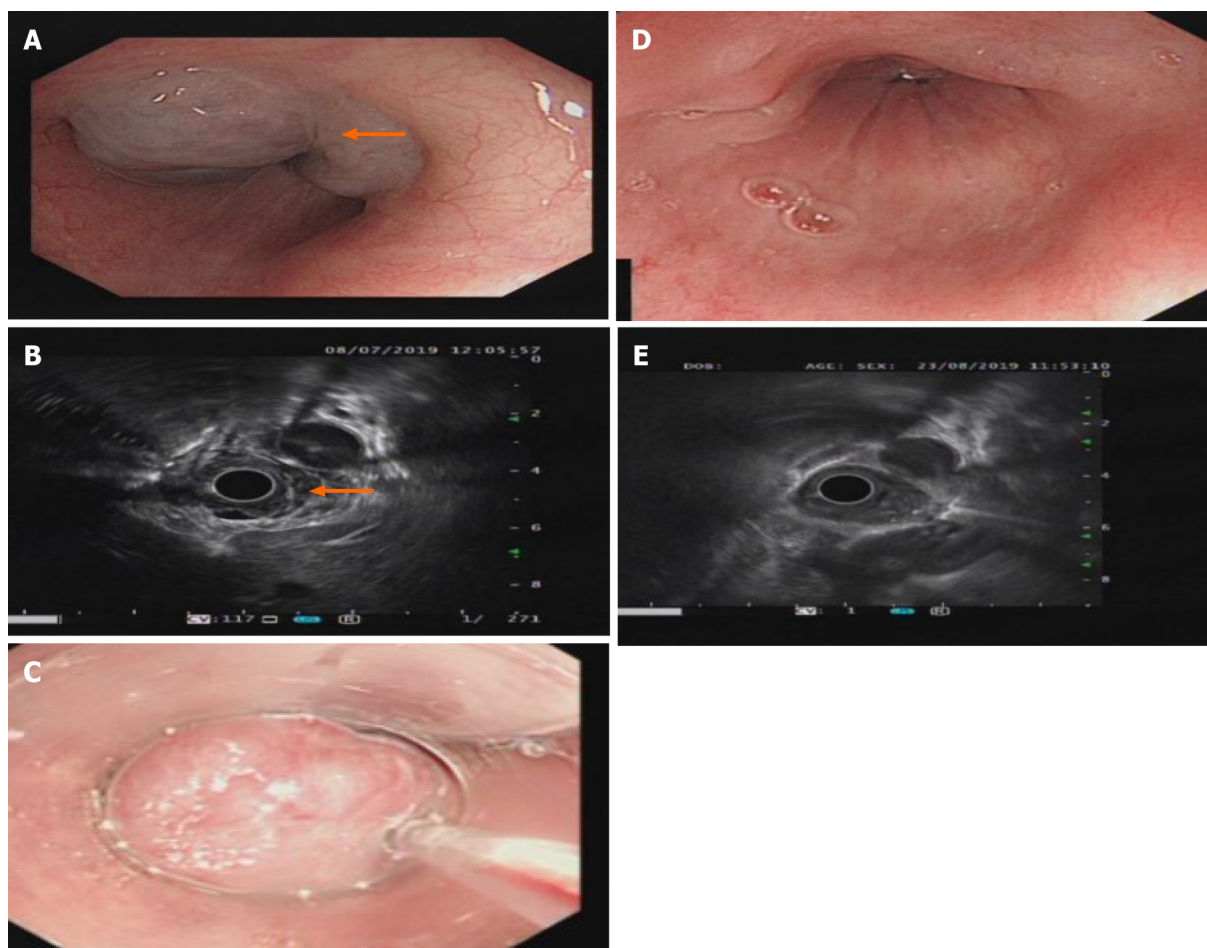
Gastroscopy and ultrasound images of the lower esophagus. A: Gastroscopy showing a bulge of about 4.0 cm × 4.5 cm × 2 cm in the lower esophagus. The mucosa was smooth and blue (as shown by the arrow in the picture); B: Endoscopic ultrasound showing lesions with multiple grids without echo structures and clear boundaries (as shown by the arrow in the picture); C: Twenty milliliters of polidocanol was injected into the hemangioma under a transparent cap with a 25G needle endoscope; D: The hemangioma at the esophageal lesion disappeared, and the mucosa was pink after treatment with polidocanol; E: Ultrasound showing that the non-echo structure disappeared after submucosal treatment with polidocanol.
